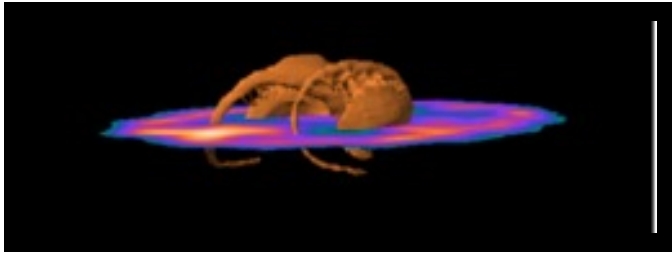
Volumetric embedded brain structure visualization in an axial SPECT section. It shows the difference in camera position in relation to previous images, according to user preferences, which enables exploration of anatomical details from different perspectives and angles.
